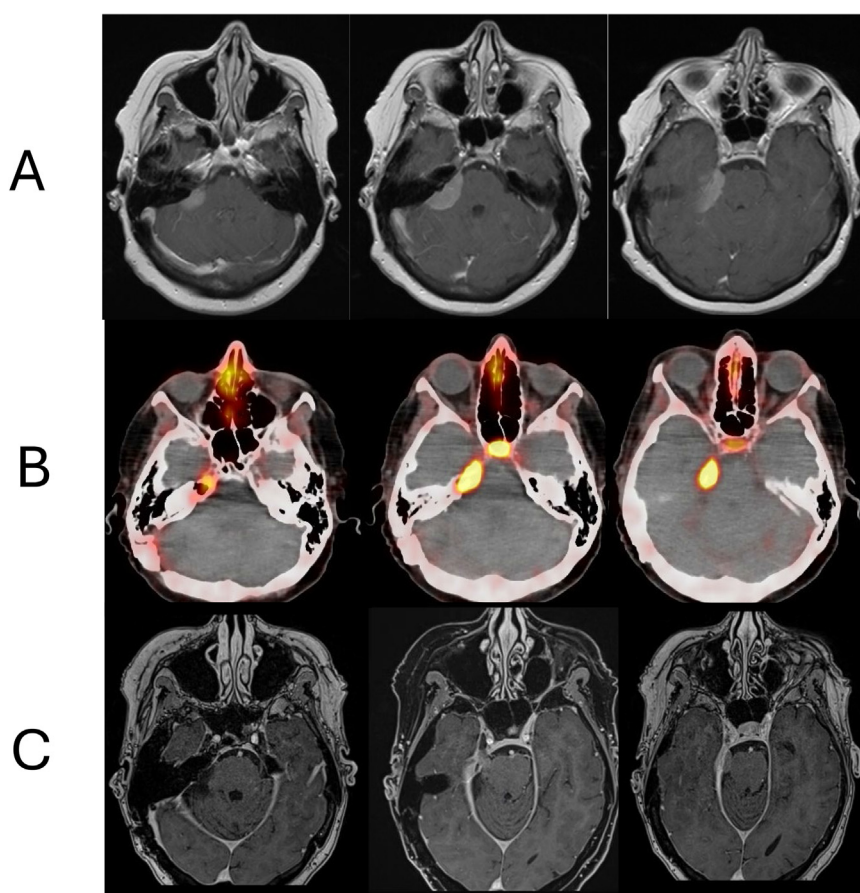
Case 5-Grade 2 in eloquent area. (A) Preoperative MRI from several years ago. (B) Postoperative PET. (C) Postoperative MRI. *Abbreviations:* MRI = magnetic resonance imaging; PET = positron emission tomography.
